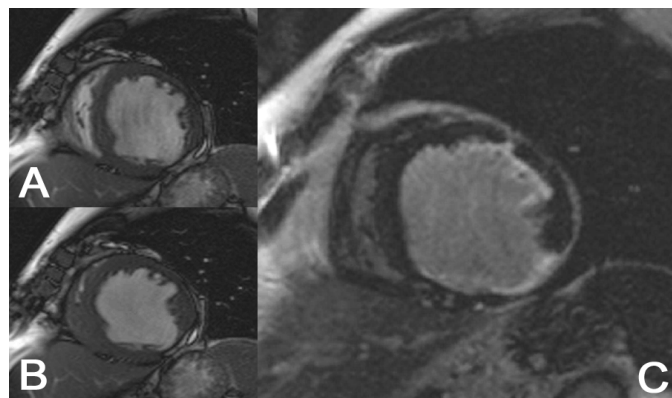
Patient with severe CAD and grossly impaired LV function: akinesis in the anterior and inferolateral wall, otherwise hypokinesia (A,B: Cine MRI in end-diastole and end-systole). C shows transmural LE in the inferolateral wall and non-transmural LE in the anterior, anterolateral and inferior wall. DL-DSE judged the inferoseptal, inferior and inferolateral wall as scar, the rest as hibernating overestimating.
